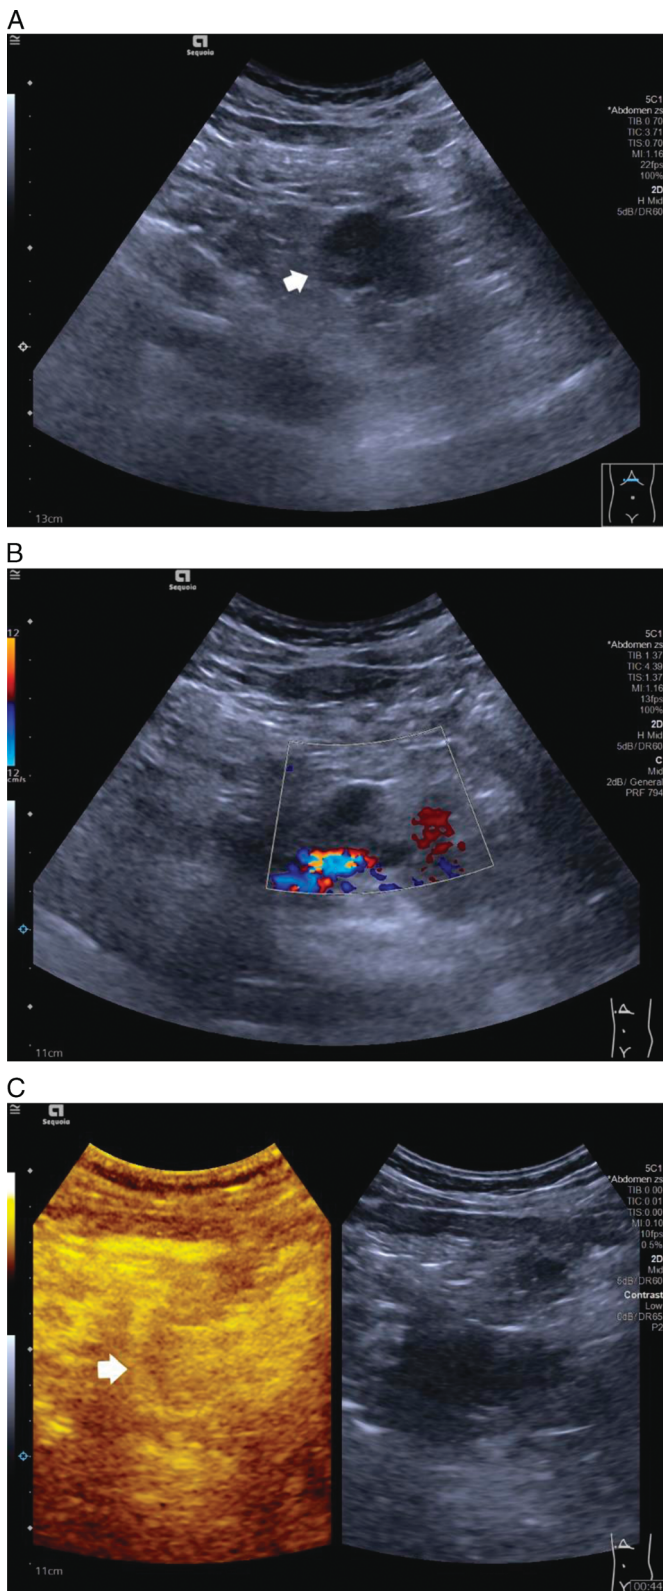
Solid pseudopapillary neoplasm of the pancreas (body and tail) in a 30-y-old man. A hypoechoic and heterogeneous lesion was visible in B-mode US (A). No blood vessels could be found inside the tumor on color Doppler imaging (B). Compared with perilesional pancreatic tissue, the lesion showed hyperenhancement in CEUS (C).
